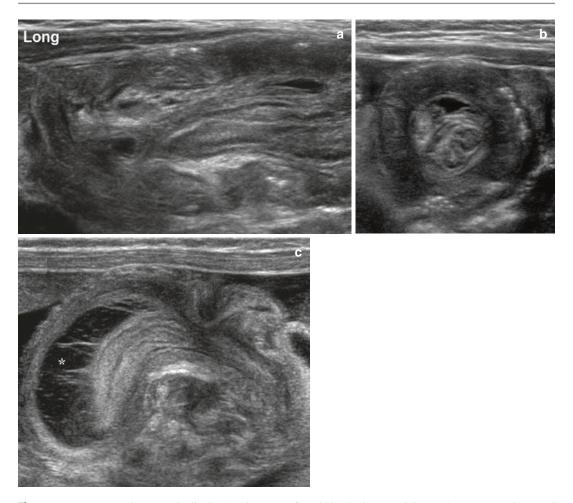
Intussusception. Longitudinal (a) and transverse (b) ultrasound images demonstrate the typical ultrasound appearance of intusussception. In transverse section, alternating rings of hypo and hyperechogencity are seen representing the intussusceptum and mesenteric
